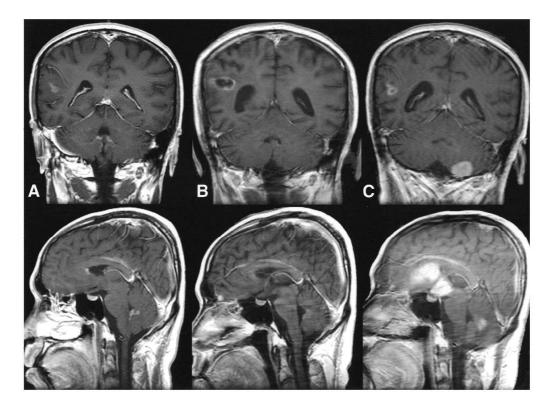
Coronal and sagittal gadolinium-enhanced T1-weighted MRIs in a patient with GBM demonstrating pathologic enhancement with solid metastasis to the fourth ventricle (A). Complete regression of the tumor immediately after delivery of focused radiation to the fourth ventricle (B). Two months later, evidence of multifocal progression of the tumor without involvement of the fourth ventricle (C).
